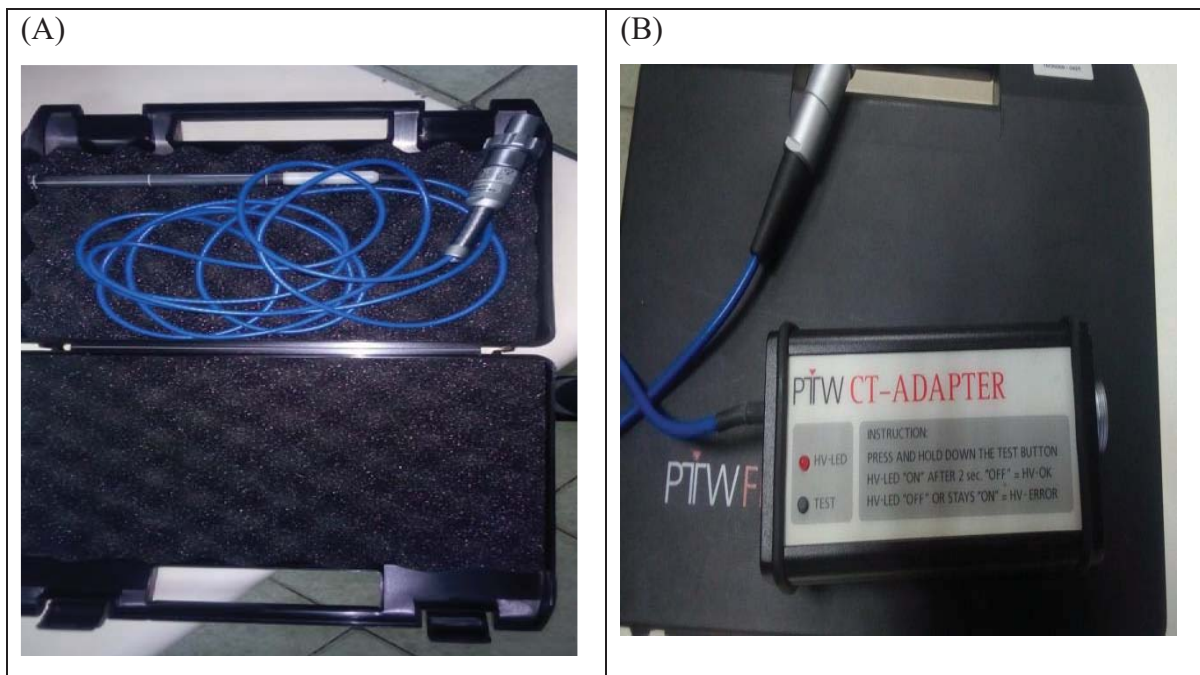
(A) 100mm Pencil Ionisation chamber (PTW, Freiburg, Germany), (B) PTW CT-adapter used in this Research
